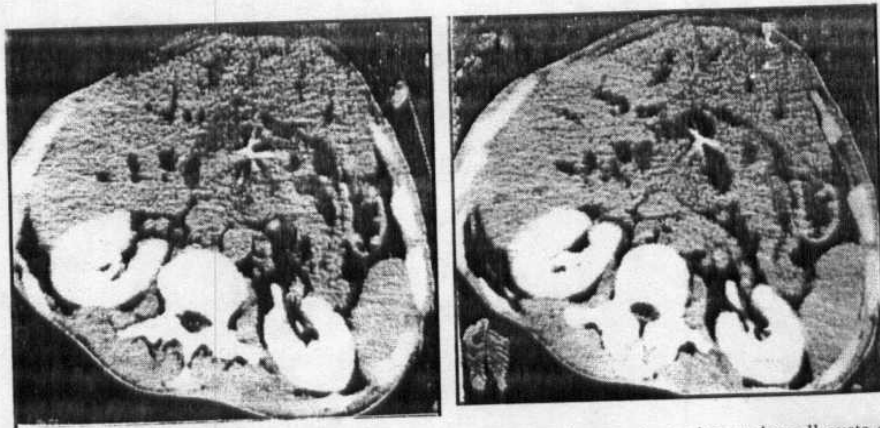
Branch duct tumor seen in the body, serial CT scans demonstrate clustered small cysts of almost the same size.
